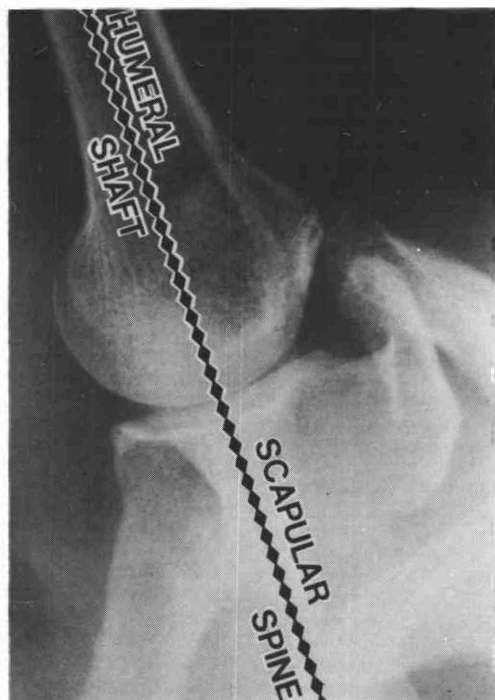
Radiograph showing the normal shoulder joint in the "zero-position". The "zero-position" is at about  $150^\circ$  of elevation in the "scapular plane", and the axis of the humerus is in line with the axis of the scapular spine.
